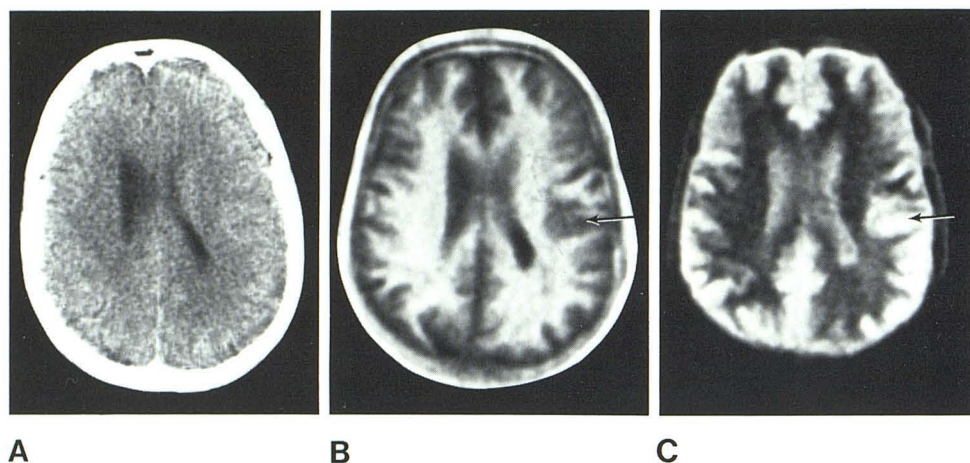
Space-occupying lesion. A, CT. B, IR_{1400/400}. C, IR_{1200/200}. Medial displacement of right lateral margin of lateral ventricle seen on CT scan (A). In addition, long T₁ lesion seen on IR scans (arrows).
